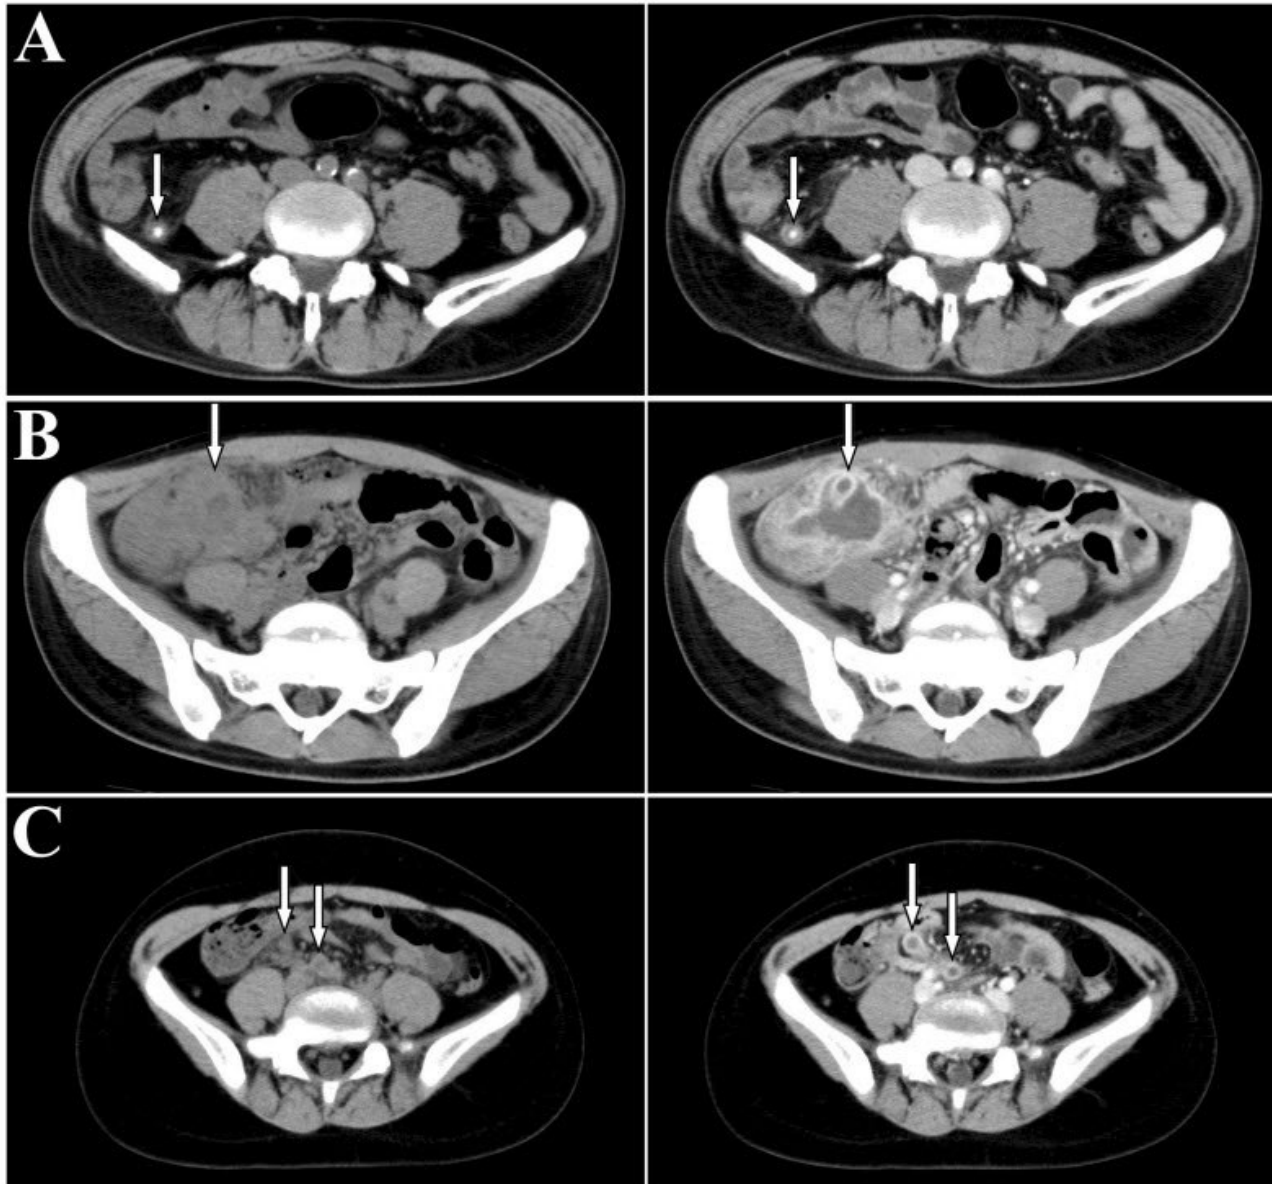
Representative images indicating appendicitis on noncontrast and enhanced CT. (A) A 62-year-old male with phlegmonous appendicitis. A fecalith and appendiceal wall thickening were detected on noncontrast and enhanced CT as indicated by an arrow. (B) A 31-year-old female with gangrenous appendicitis. Abscess formation was clearly detected on enhanced CT as indicated by an arrow. (C) A 8-year-old girl with phlegmonous appendicitis. Detection of vermiform appendix was difficult on noncontrast CT, whereas enlarged appendix with appendiceal wall thickening was clearly detected on enhanced CT as indicated by arrows.
